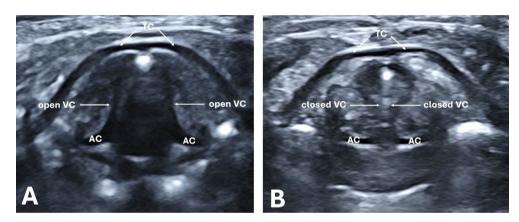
Position of the vocal cords on ultrasonography recordings that are scored as open (A) or closed (B). VC, vocal cord; AR, arytenoid cartilage; TC, thyroid cartilage.
